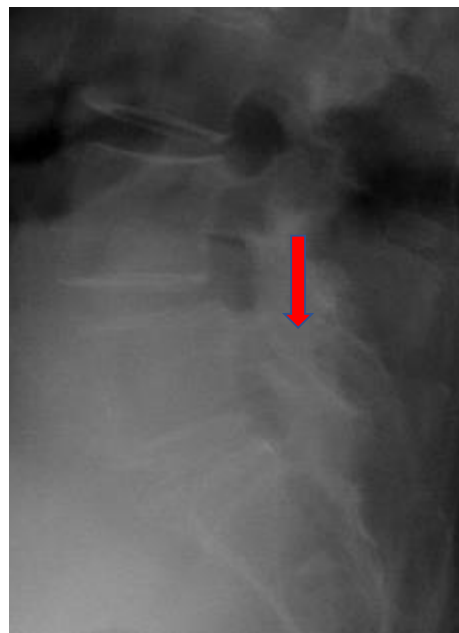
Standard X-Ray (LL view): Baastrup's Syndrome (arrow).
